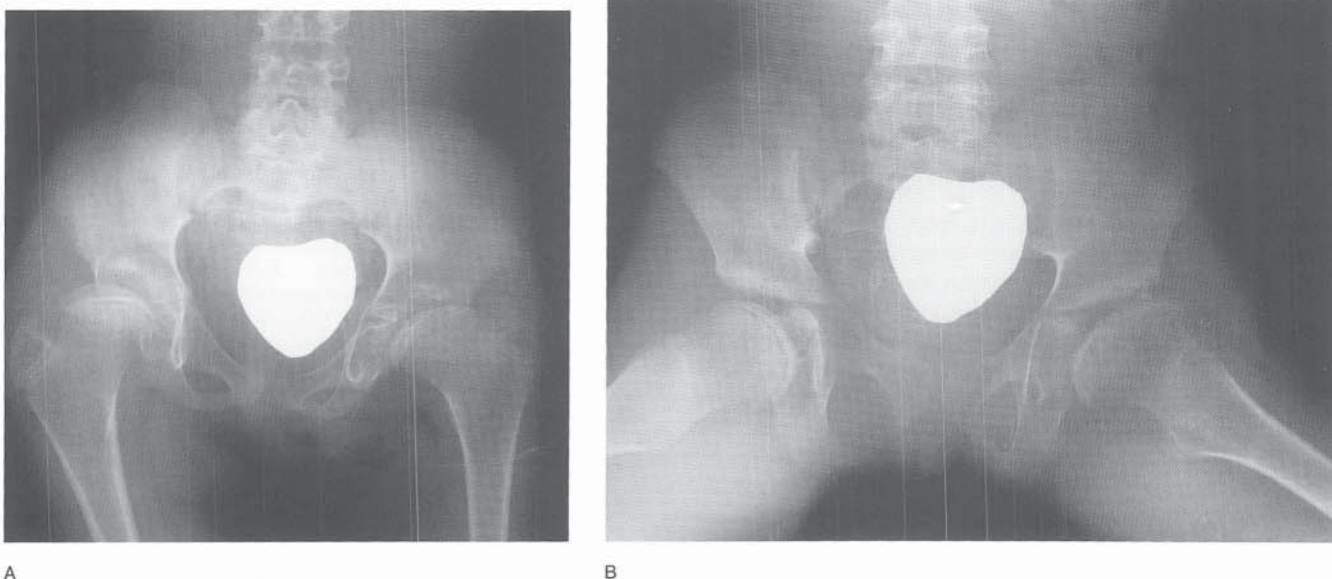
A and B, AP and frog-leg radiographs of a 9-year-old girl with multiple epiphyseal dysplasia. Both femoral heads are irregular and mushroom-shaped.
